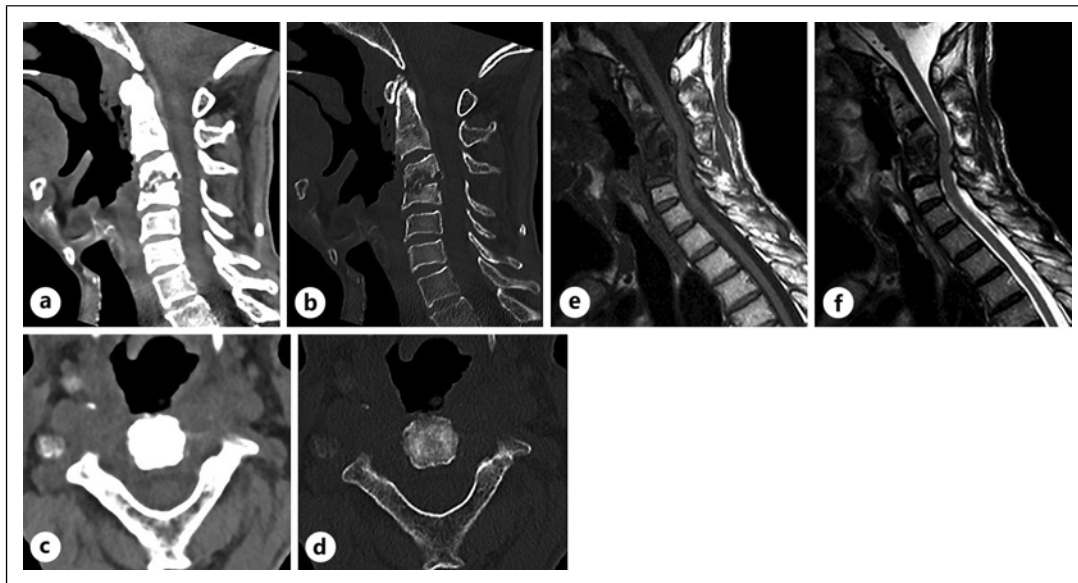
CT of the cervical spine sagittal reconstructions in soft tissue (a) and bone (b) windows and axial sections in soft tissue (c) and bone (d) windows display disc-vertebral changes centered on the C3–C4 disc with extensive erosions in the vertebral endplates and with a small soft tissue component in the epidural and paravertebral spaces. In the immediate proximity, there is an ulceration of the posterior wall of the oropharynx with a fistulous tract extending to the pre-vertebral space, consistent with radiation necrosis. Also noteworthy is the cervical kyphotic deformity contributing to the stenosis of the central spinal canal. The corresponding MRI sagittal sections in T1W (e) and T2W (f) images show more accurately the extent of the inflammatory process and the bone marrow edema of the vertebrae extending from the lower third of C2 to the lower endplate of C4, as well as the stenosis of the central spinal canal with effacement of the pre- and retromedullary subarachnoid space. However, no areas of spinal cord edema or foci of myelomalacia are seen to suggest spinal cord distress.
